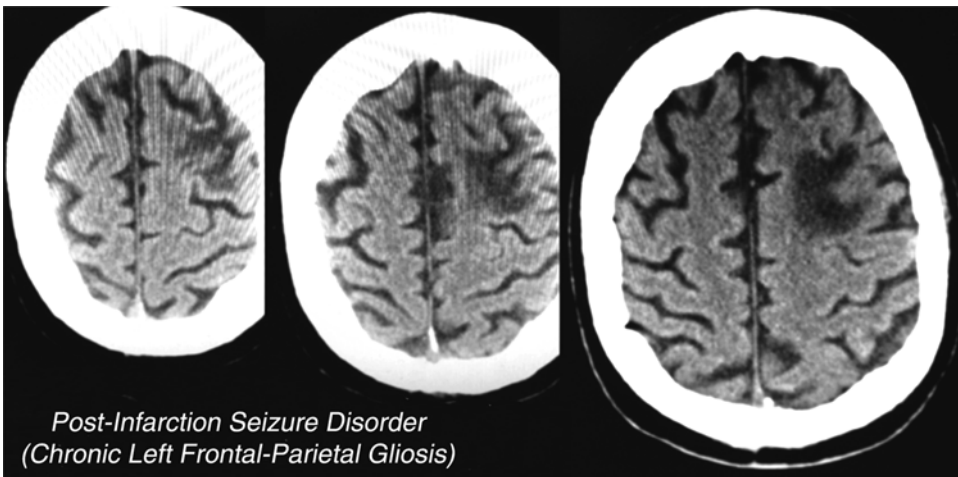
Post-infarction epilepsy: CT findings
